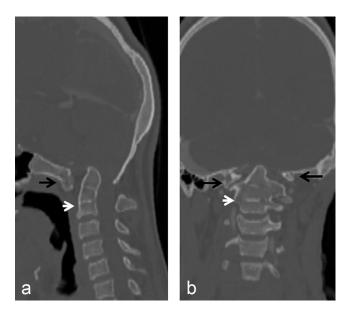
(A) Sagittal computed tomography angiography (CTA) image through the neck in bone window in an 11year-old boy shows C2-C3 cervical vertebral fusion (small white arrow) consistent with Klippel-Feil syndrome (KFS). The C1 vertebra (atlas) is also fused with occiput, consistent with occipitalization of the atlas (C1) vertebra (black arrow). Tip of the dense process is just above the level of foramen magnum, consistent with basilar invagination. (B) Coronal CTA image through the neck in bone window in an 11-year-old boy shows C2 -C3 cervical vertebral fusion (small white arrow) consistent with KFS. The C1 vertebra (atlas) is also fused with occiput, consistent with occipitalization of the atlas (C1) vertebra (black arrow). Tip of the dense process is just above the level of foramen magnum, consistent with basilar invagination.
